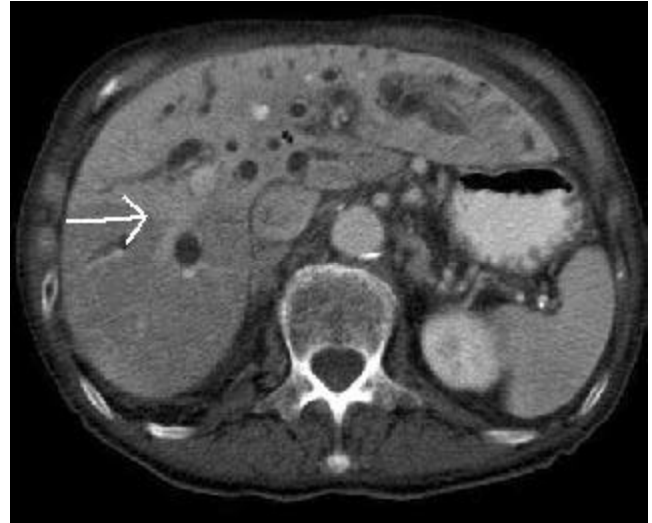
Peribiliary THAD: CT scan of a different patient with pancreatic carcinoma demonstrating a linear, branching pattern of increased enhancement (arrow), along the dilated biliary tree.
